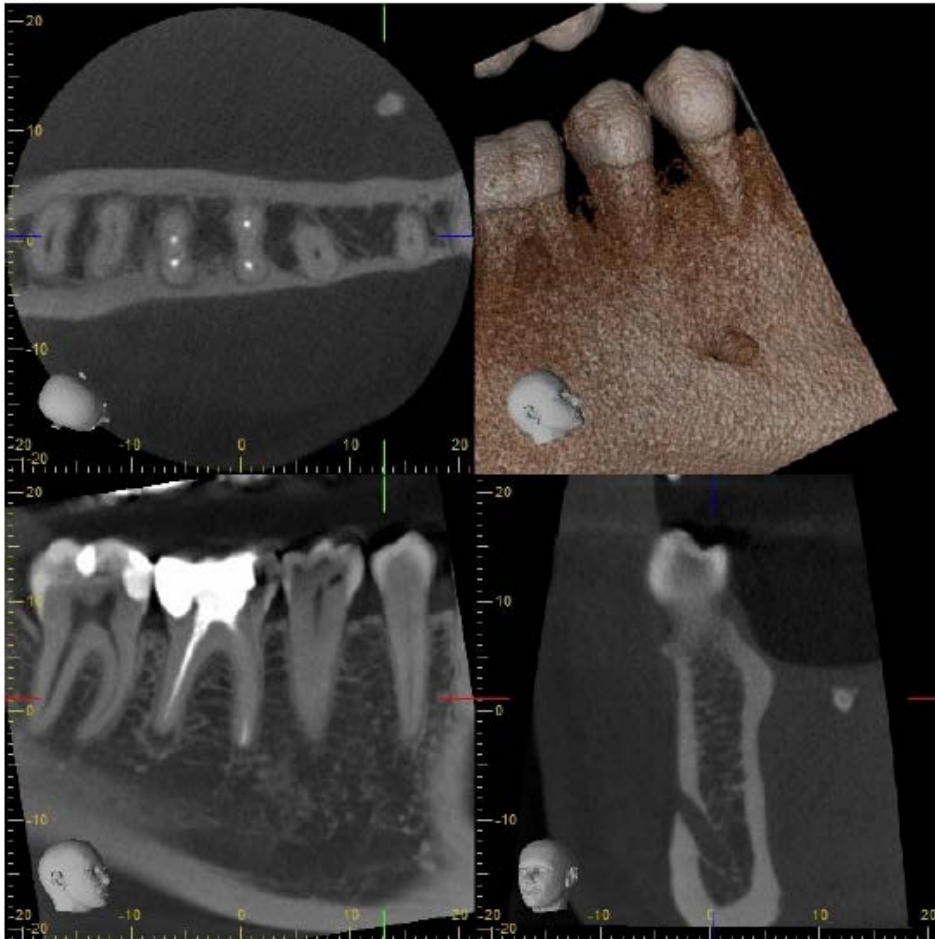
A fortuitous finding emerging during pre-treatment X-ray diagnosis – a sialolithiasis in the excretory duct of the *glandula sublingualis* representing the probable cause of an earlier-experienced massive swelling in the soft-tissue area.
